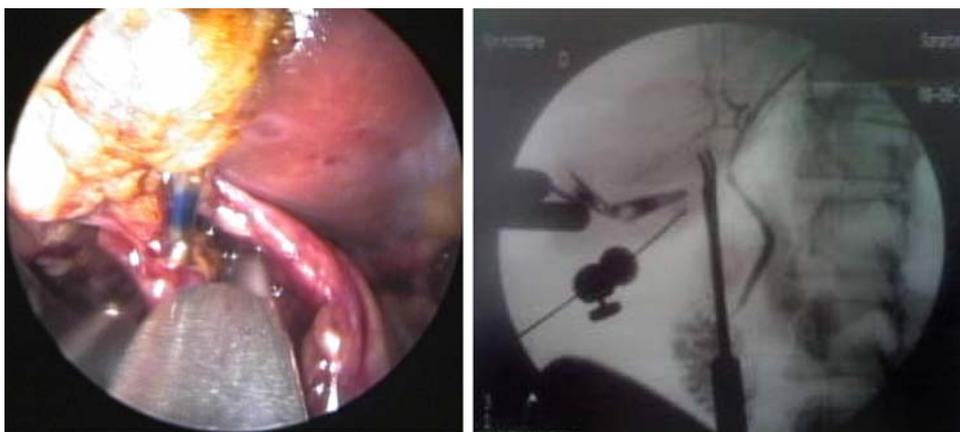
Intraoperative cholangiography. TD-magnets can be seen in the X-ray image
